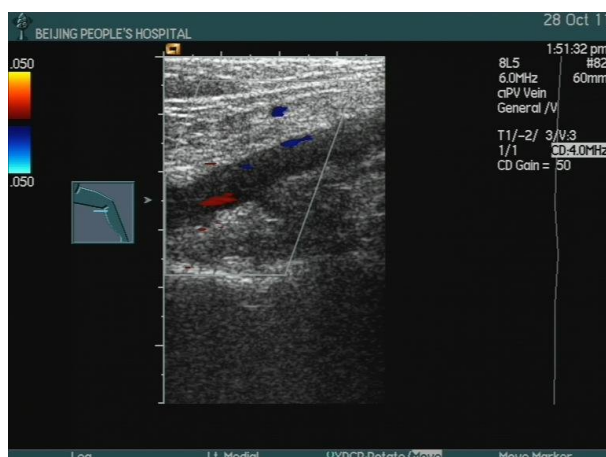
The ultrasonic blood flow imaging of the left popliteal vein with thrombosis induced by oral administration of CBZ. The blue spot- and plaque-like and the red plaque-like blood flow imaging showed a small amount of recanalization in the left popliteal vein
